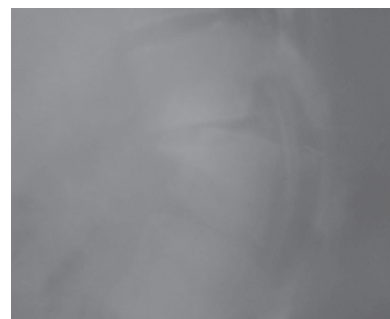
Dorsolumbar spine radiograph after eight years showing worsening of deformity
